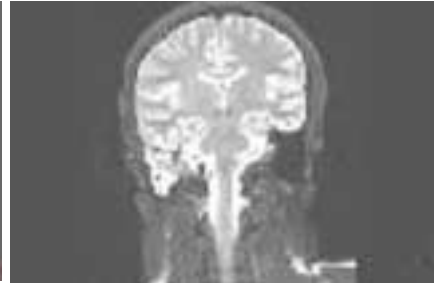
Magnetic resonance imaging section demonstrating mastoid inflammation, coronal section.
